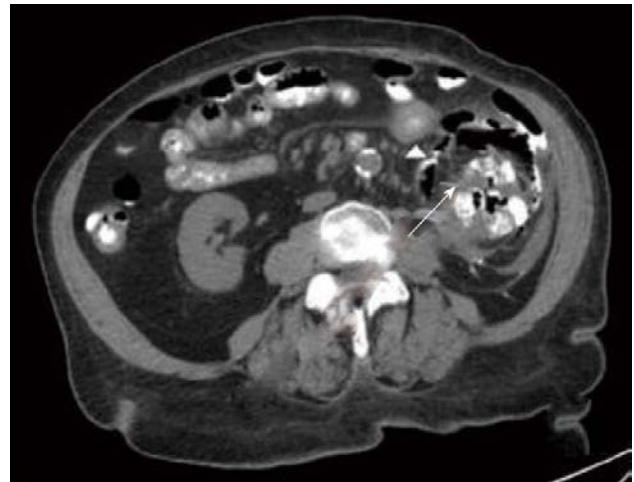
Computed tomography scan of the urinoma in the proximity of the right kidney.
